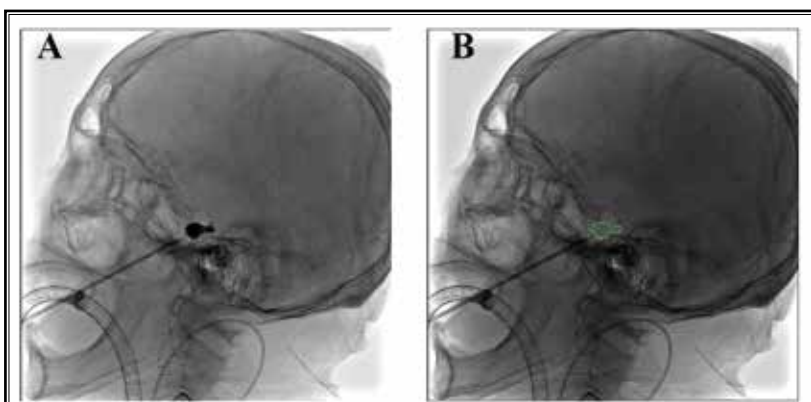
Image morphological feature extraction. A,B A region of interest was manually drawn on the lateral plain film. Radiomic features were extracted from the radiographs to quantify their shape characteristics.
